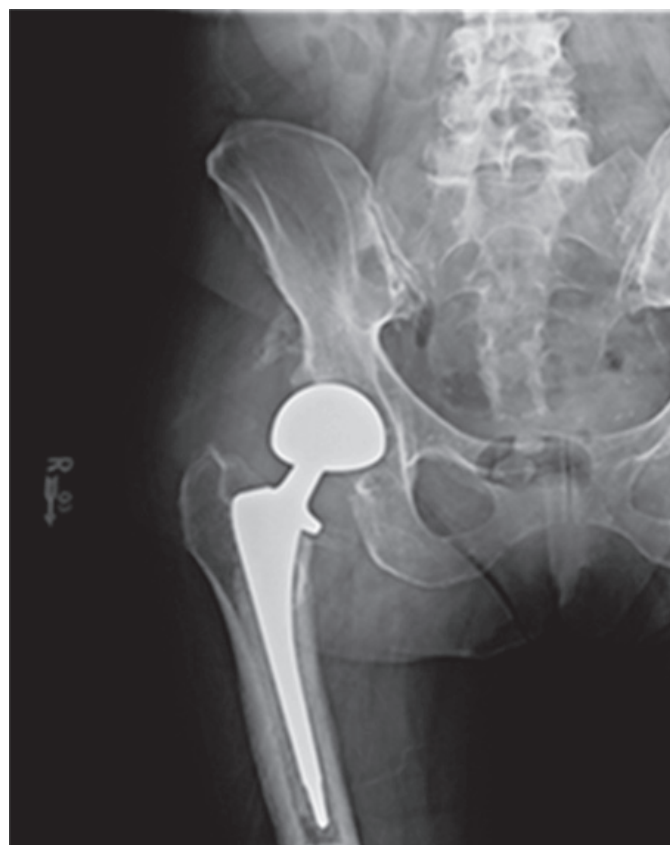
Radiograph of right hip, still reduced at third month post-fracture table reduction.
